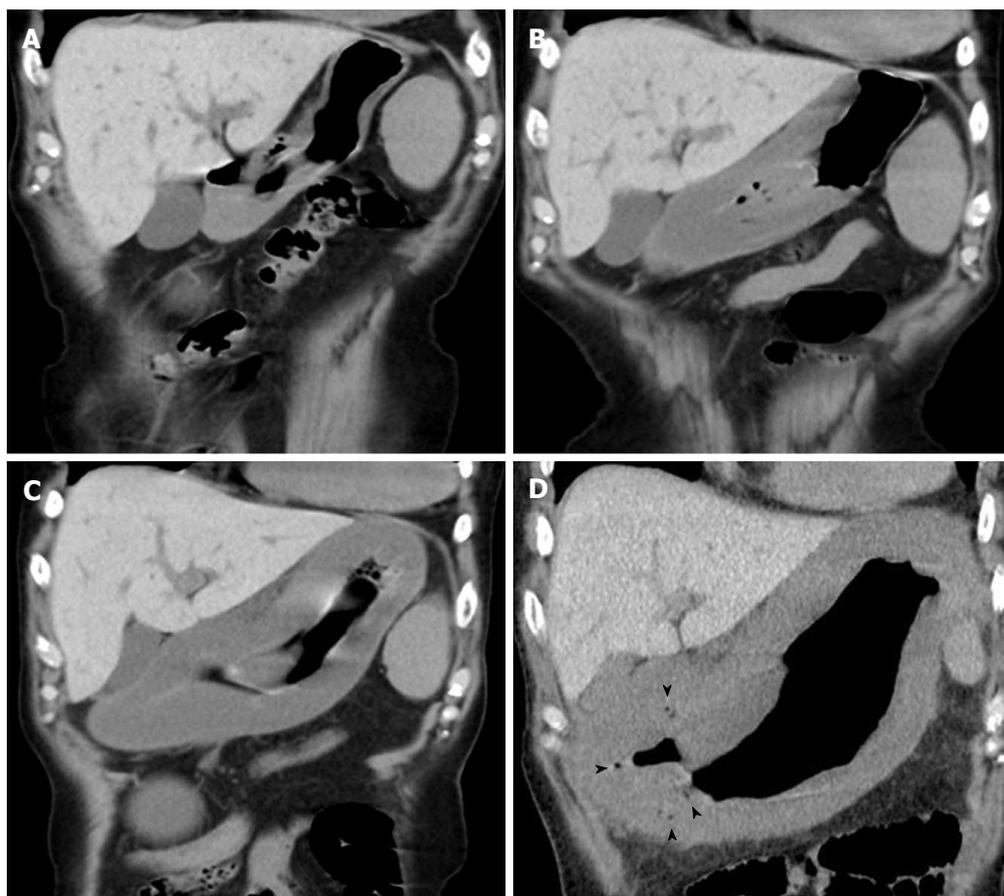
Abdominal computed tomography images show rapid progression of gastric wall hypertrophy. Twenty days before onset (A) and at 4 h (B), 6 h (C), and 10 h (D) after onset. Arrowheads in (D) indicate intramural gas.
